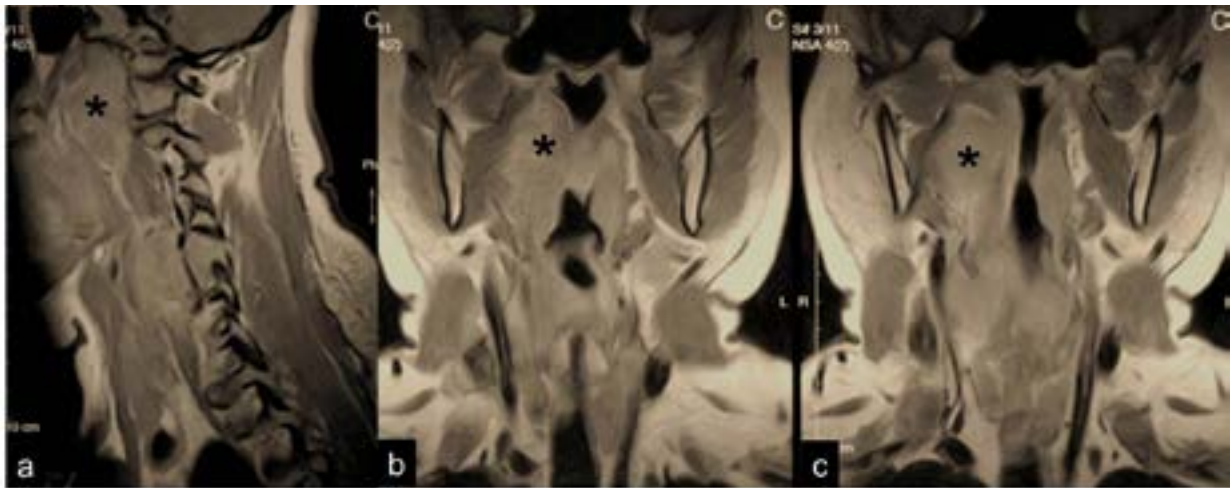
MRI of cervical spine post IV Gad. - (a) Sagittal, (b & c) Coronal, showing a minimally enhancing soft tissue mass at the right nasopharynx (asterisk) in keeping with the HPE proven nasopharyngeal carcinoma.
